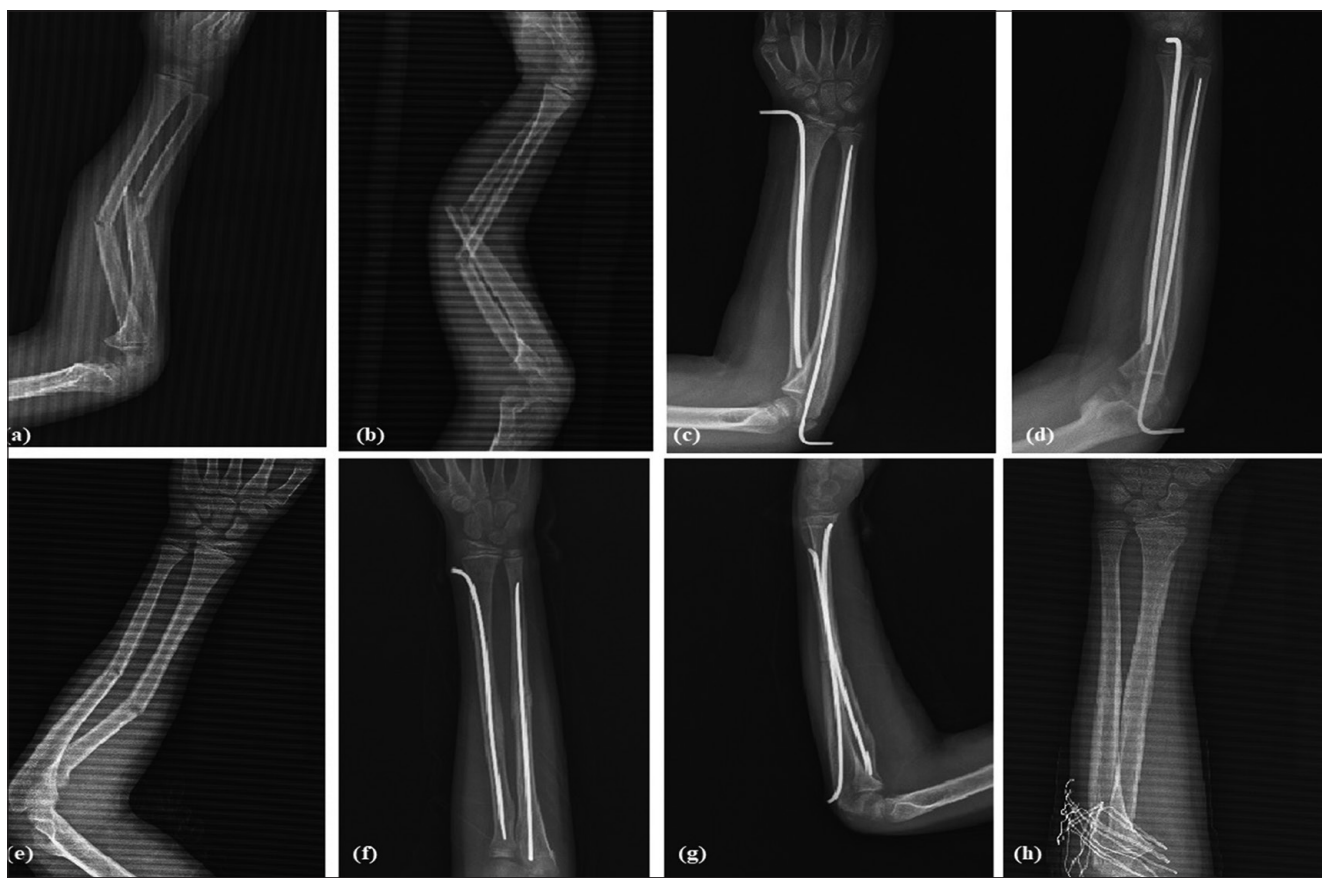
(a, b) Anteroposterior and lateral view of a 5-year-old boy who sustained both bone forearm fractures on the left side. (c, d) Anteroposterior and lateral view X-rays of forearms after ESIN, the nail ends were left exposed. (e) Post-operative radiograph at 5 months showing re-fracture. (f, g) Anteroposterior and lateral view X-rays of forearms after ESIN, the nail ends were left buried. (h) Post-operative radiograph after hardware removal at 8 months showing bony union.
